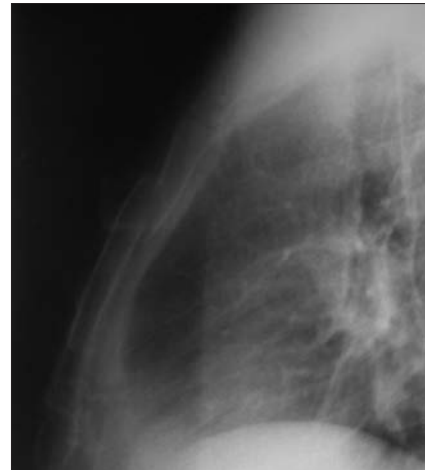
Displaced sternum fracture on lateral X-ray
